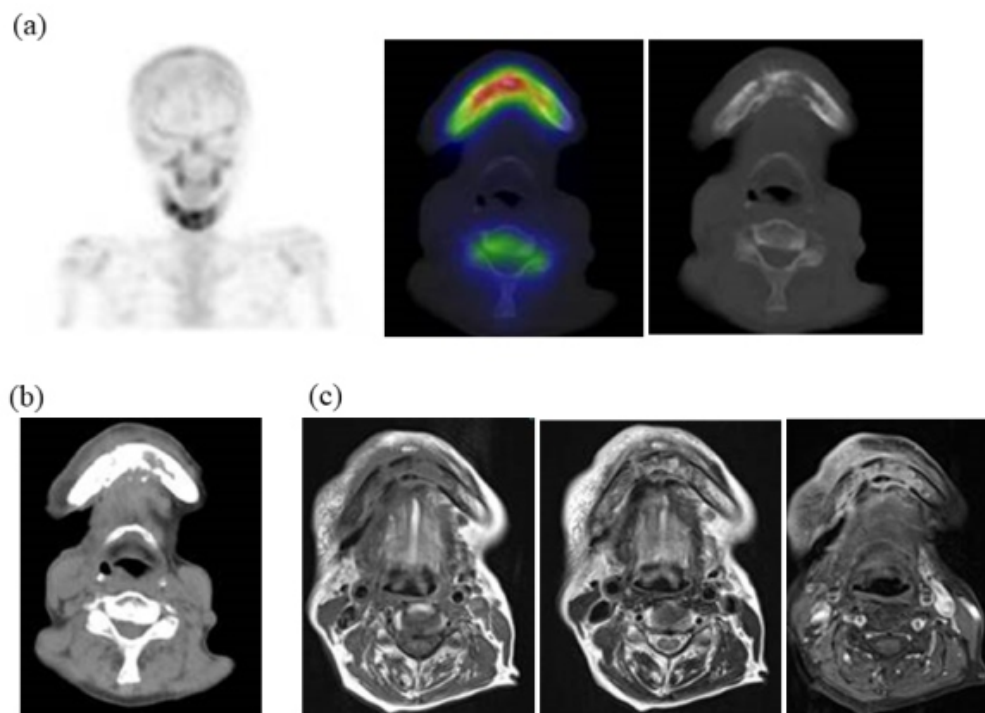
A 79-year-old female with mandibular osteoradionecrosis, who previously received chemoradiotherapy for oropharyngeal cancer 20 months ago. (a) Bone SPECT/CT shows medium uptake and combined osteolytic and sclerotic change in the mandible. Maximum SUV, SUVpeak, SUVmean, MLV, and TLU of the lesion are 6.46, 5.49, 3.84, 33.32, and 127.86 respectively. (b) CT shows combined osteolytic and sclerotic lesion in the mandible. (c) MRI shows decreased marrow signal intensity on T1-weighted image and heterogeneous increased marrow signal intensity on T2-weighted image with heterogeneous enhancement in the mandible.
